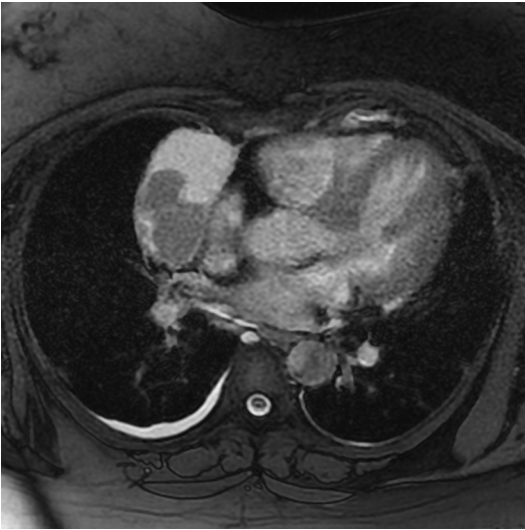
Cystic thymoma. Axial T2-weighted MR image with fat suppression shows a large, right prevascular mediastinal cystic mass with T2 hyperintense signal corresponding to fluid in the lesion as well as eccentric soft tissue nodules.
